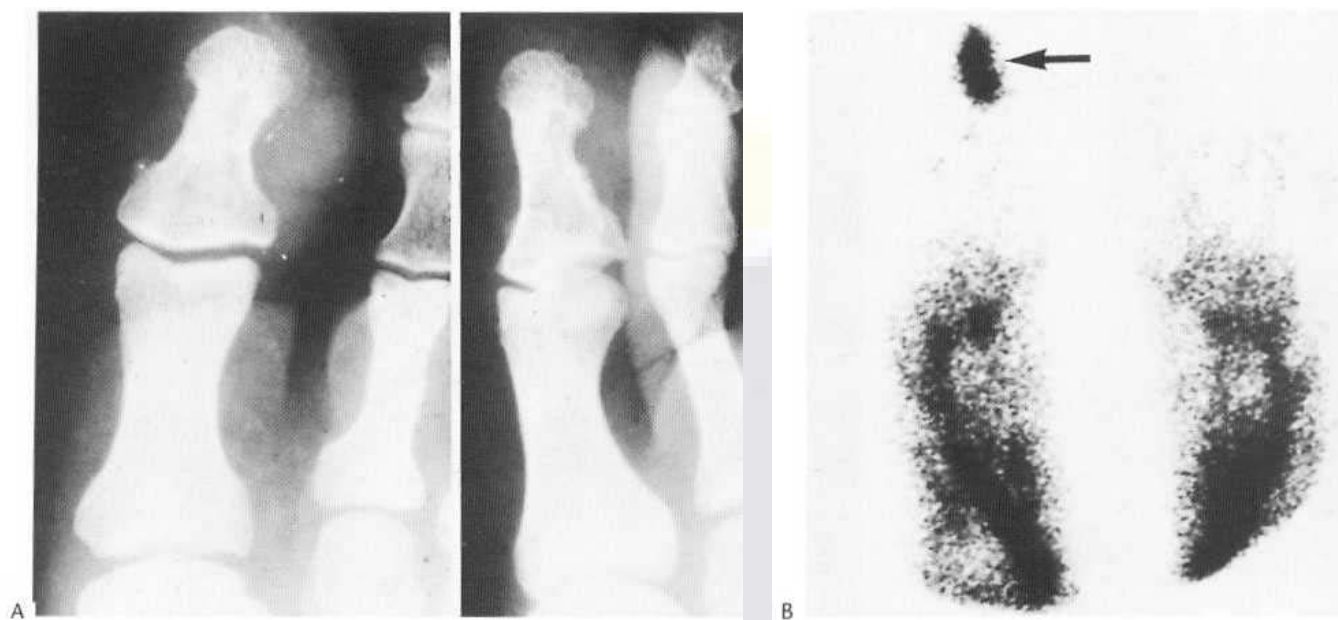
Soft-tissue haemangioma of the great toe. This patient complained of a swollen great toe with a purple area of discoloration. (A) A plain film reveals soft-tissue swelling and pressure erosion of the plantar aspect of the distal phalanx. (B) A blood-pool scan confirms an intense focus of activity (arrow) corresponding to the cavernous haemangioma.
